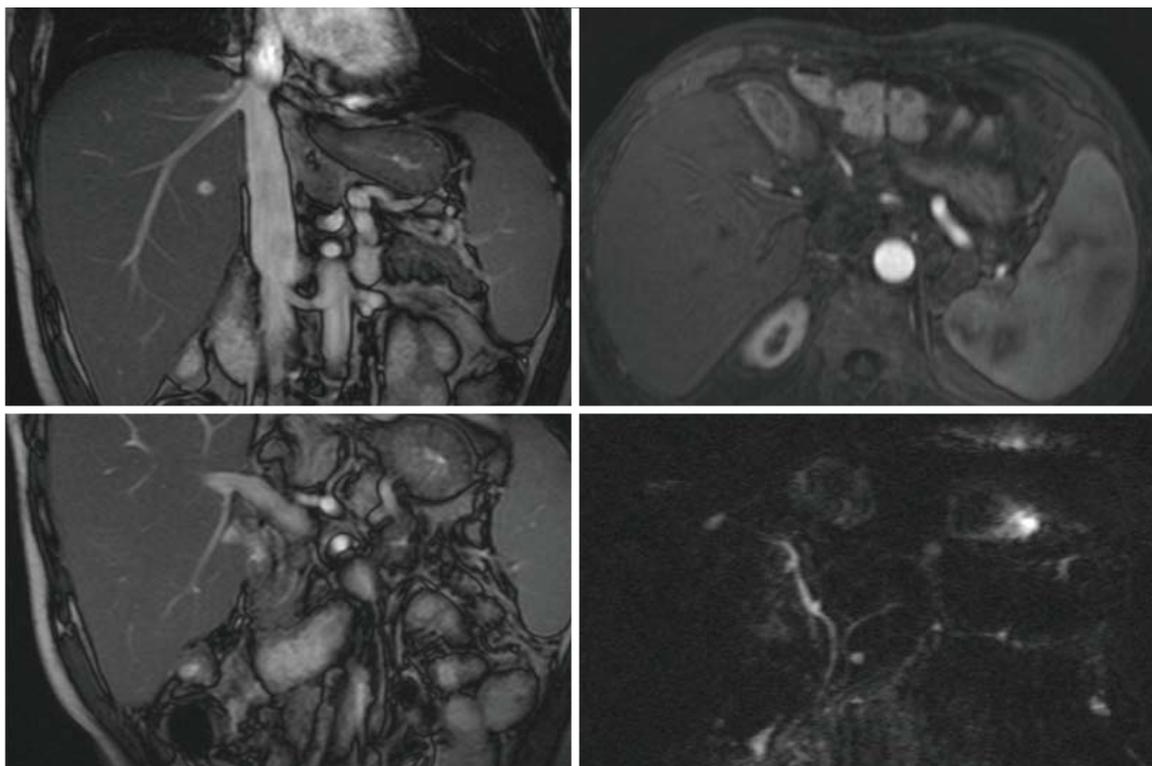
Magnetic resonance imaging screening for liver graft vascular or biliary complications.
